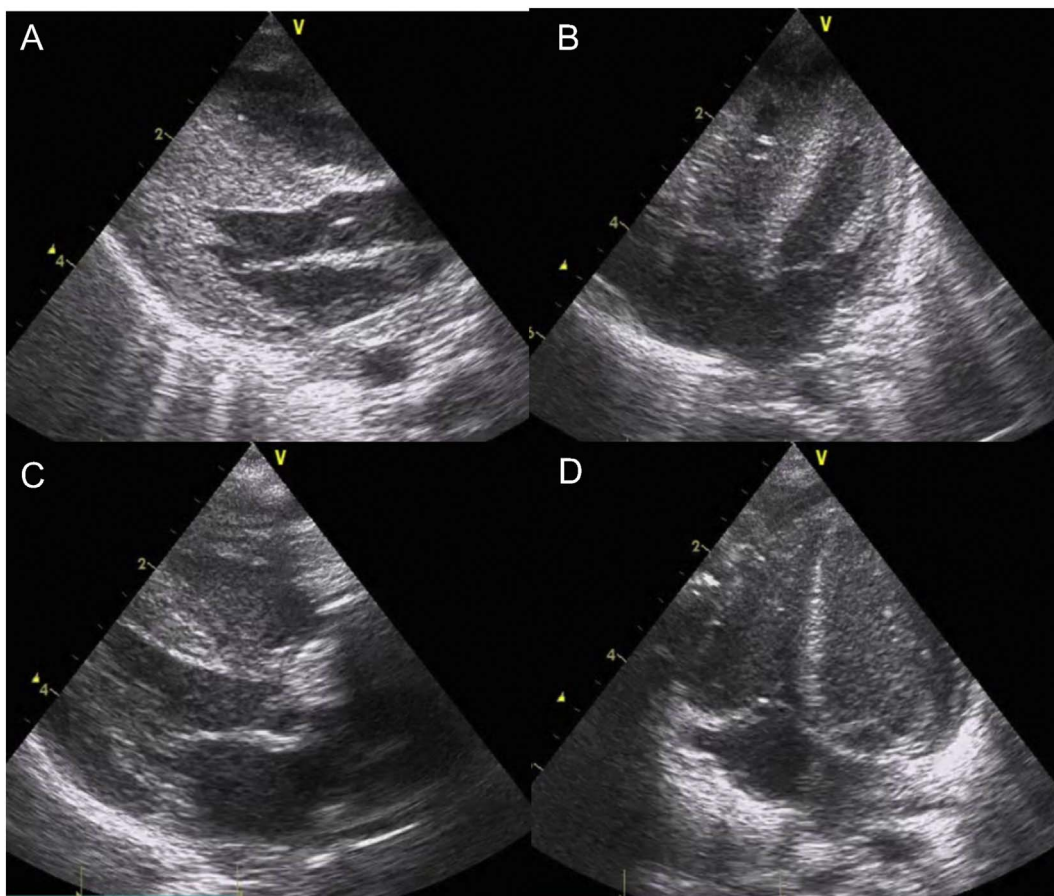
Echocardiography. A,B: Onset. Echocardiography showed hypertrophy of the cardiac muscle, especially in the apex, and the left ventricular ejection fraction was reduced (65%). C,D: After treatment. Hypertrophy of the cardiac muscle and cardiac function were improved.
